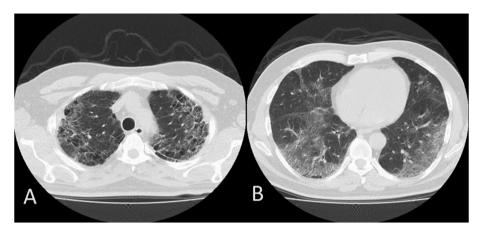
Control HRCT findings (progression with the honey comb pattern and pulmonary fibrosis added to Fig. 1 findings).
